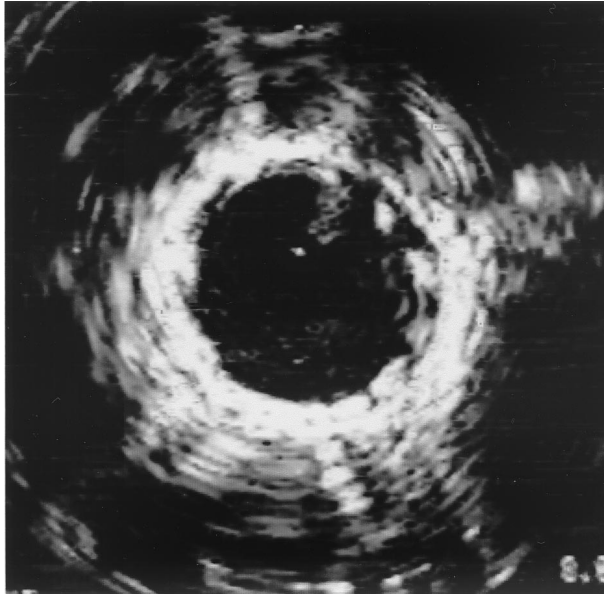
Intravascular ultrasound imaging. The Palmaz stent P-308 shows no intimal growth, 22 months after stent implant. Some tissue prolapse is noted at the 1 o'clock position.
